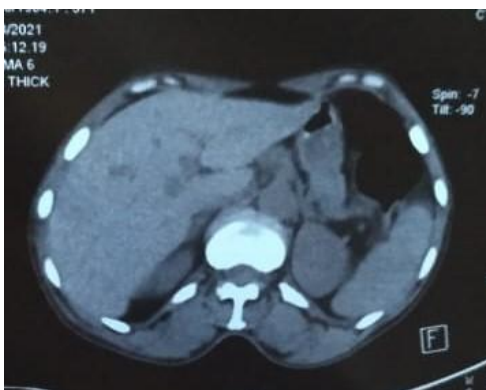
CT scan images of the liver...
